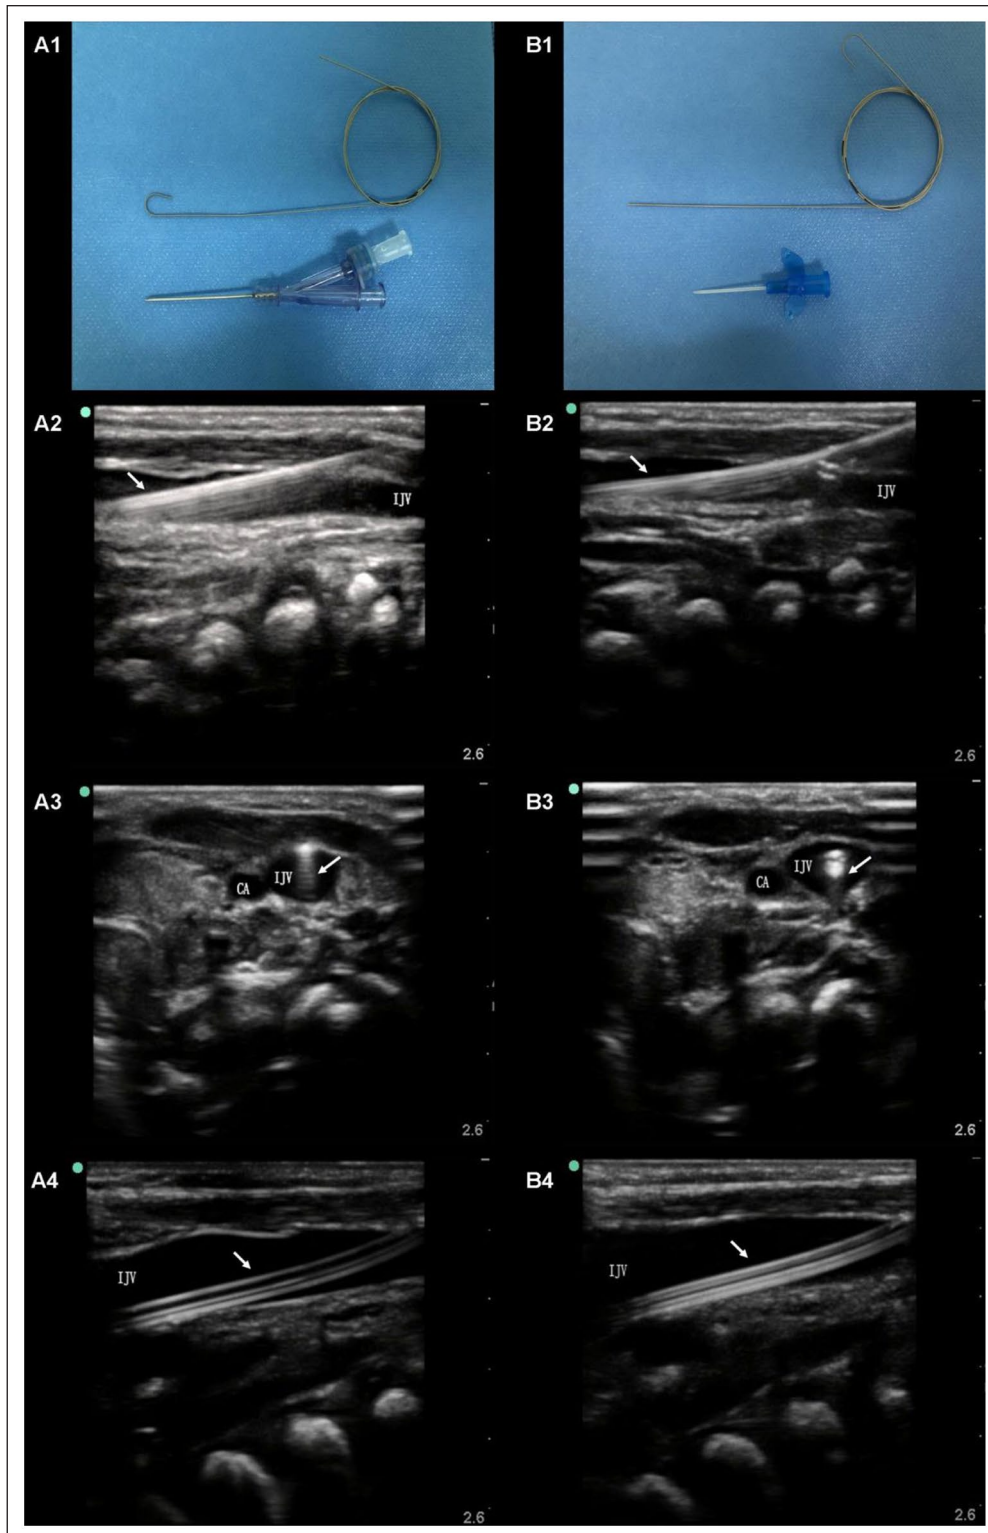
Ultrasonographic images of right IJV catheterization in a 17-day-old infant (Needle group, A1–A4) and in a 4-day-old infant (Cannula group, B1–B4).
